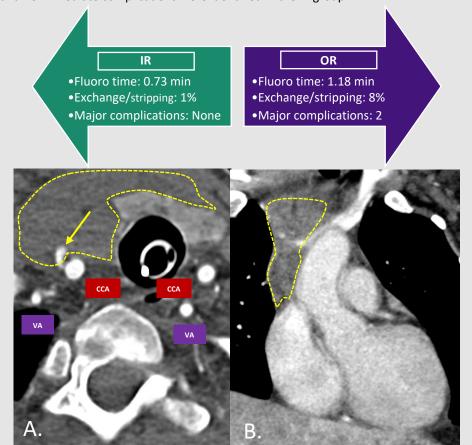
44-year-old female with recent diagnosis of metastatic colon cancer, scheduled for surgical chest port placement prior to initiation of chemotherapy. Intraprocedural arterial access with brisk pulsatile blood after dilator removal was noted and hemoptysis. A. Axial view Chest CTA shows focal area of extravasation in the right common carotid artery (arrow) with illdefined collection causing mass effect on the trachea and thyroid (dashed line). B. Coronal view shows hyperdense collection tracking into the mediastinum consistent with hematoma (dashed line). The patient was emergently transferred to a tertiary center for stent placement.
